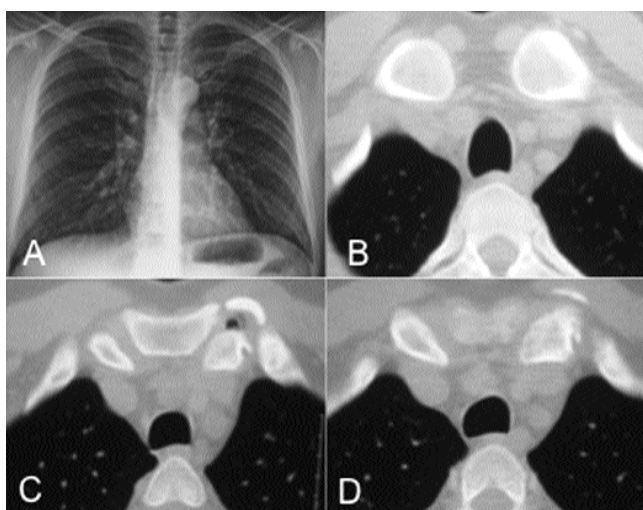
Plain film radiograph and Computed tomography scanning demonstrating regression of the condensing osteitis. There is an inferior spur, joint space narrowing, vacuum phenomenon in the joint space as a sequela.
